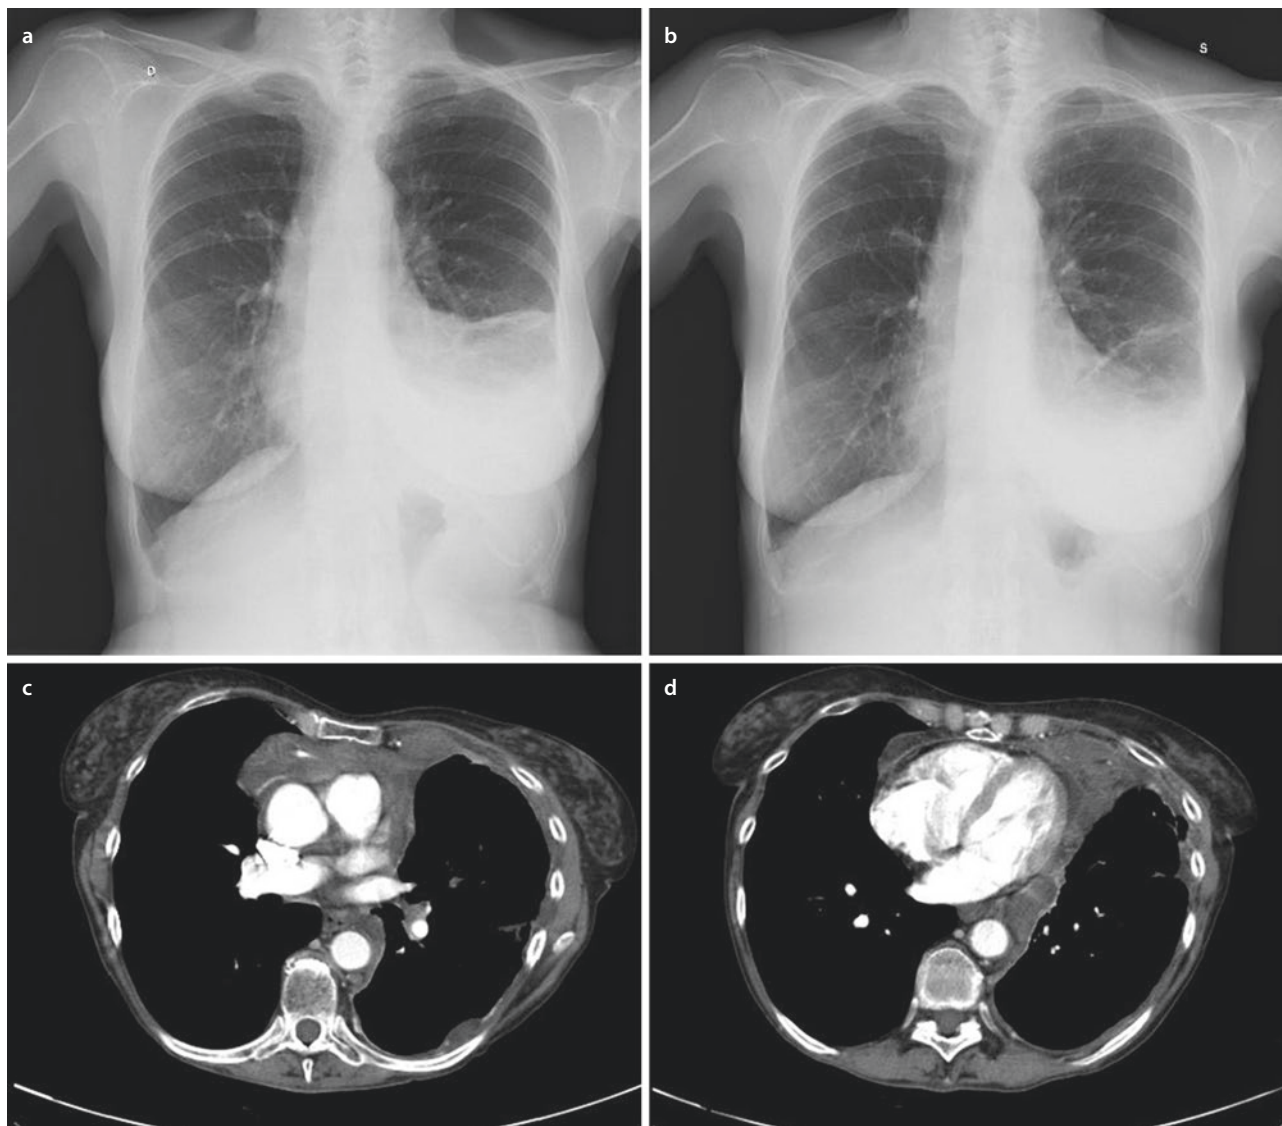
Chest X-ray with left pleural effusion a and corresponding chest X-ray b and CT scan c, d after thoracentesis
